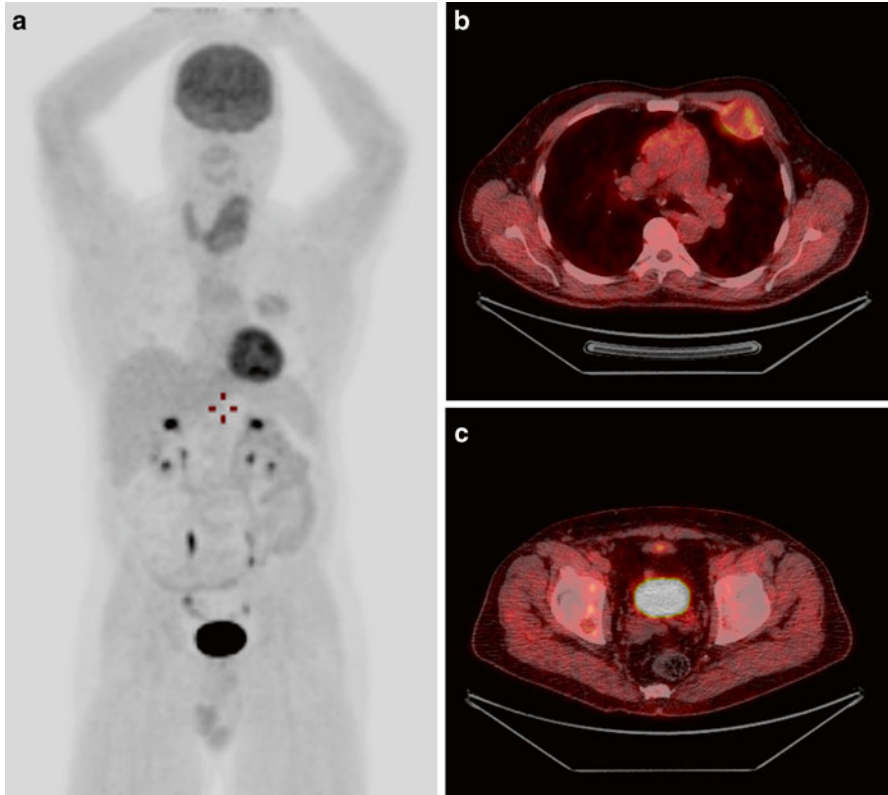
^{18}F Fluorodeoxyglucose positron emission tomography (^{18}F FDG PET)/CT scan performed at initial staging. (a) ^{18}F FDG PET/CT whole-body maximum intensity projection (MIP) showing uptake in 6 cm left lobe thyroid cancer (SUVmax: 6) and in the third left rib (SUVmax: 3.4) corresponding to a 4 cm lytic lesion. There was no significant FDG uptake in multiple lung nodules of few millimeters diameter. (b) Axial fusion image showing high FDG uptake in the third left rib lesion. (c) Axial fusion image showing no significant FDG uptake in the right ischial lesion
